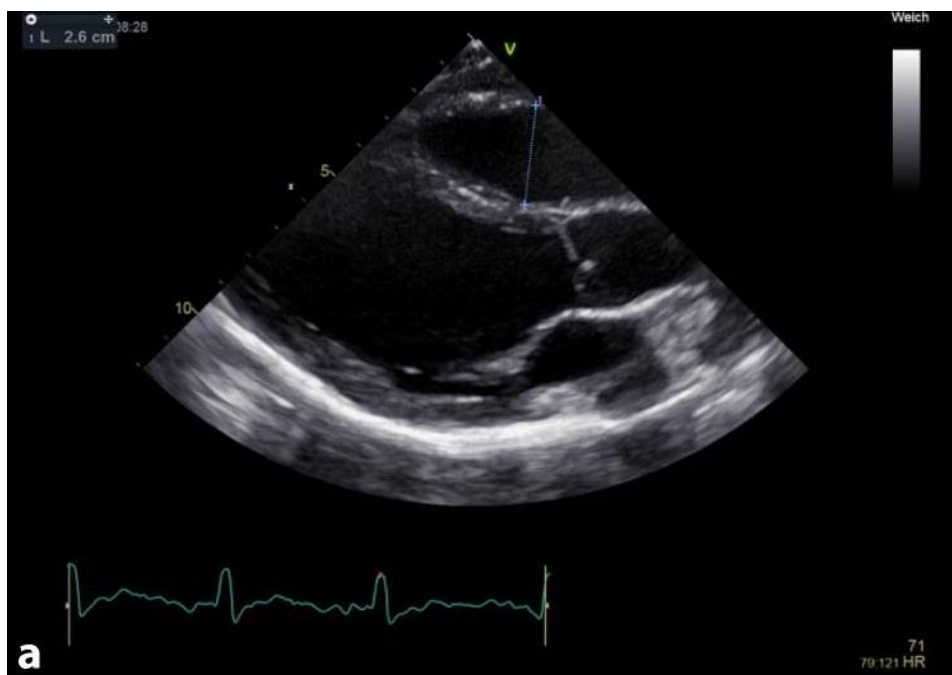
Proximal human right ventricular outflow tract on parasternal long axis view
